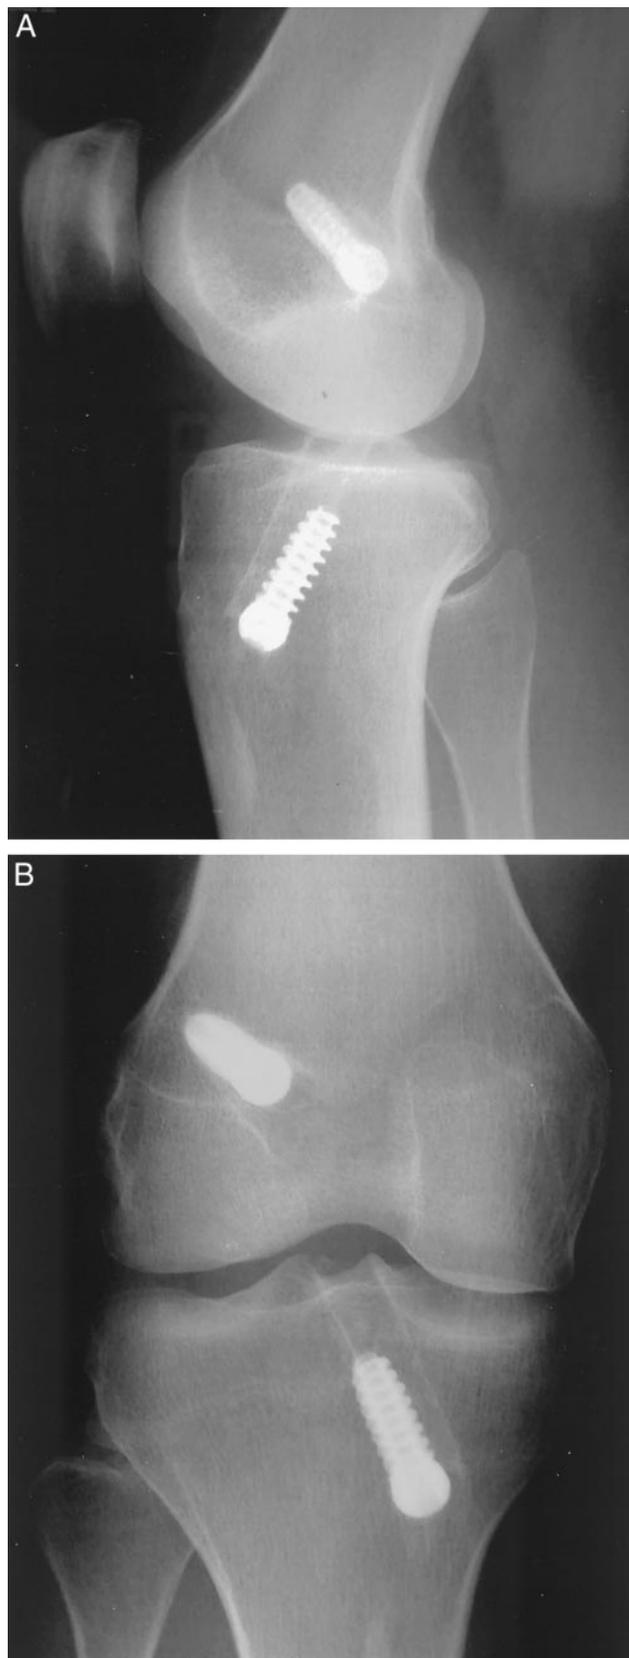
Postoperative lateral (A) and AP (B) radiographs showing the locations of the tibial and femoral tunnels.
